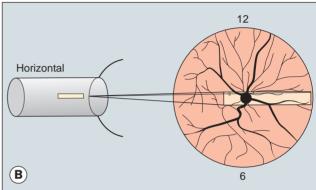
Technique of ultrasound scanning of the globe. (A) Vertical scanning with the marker pointing towards the brow; (B) horizontal scanning with the marker pointing towards the nose
